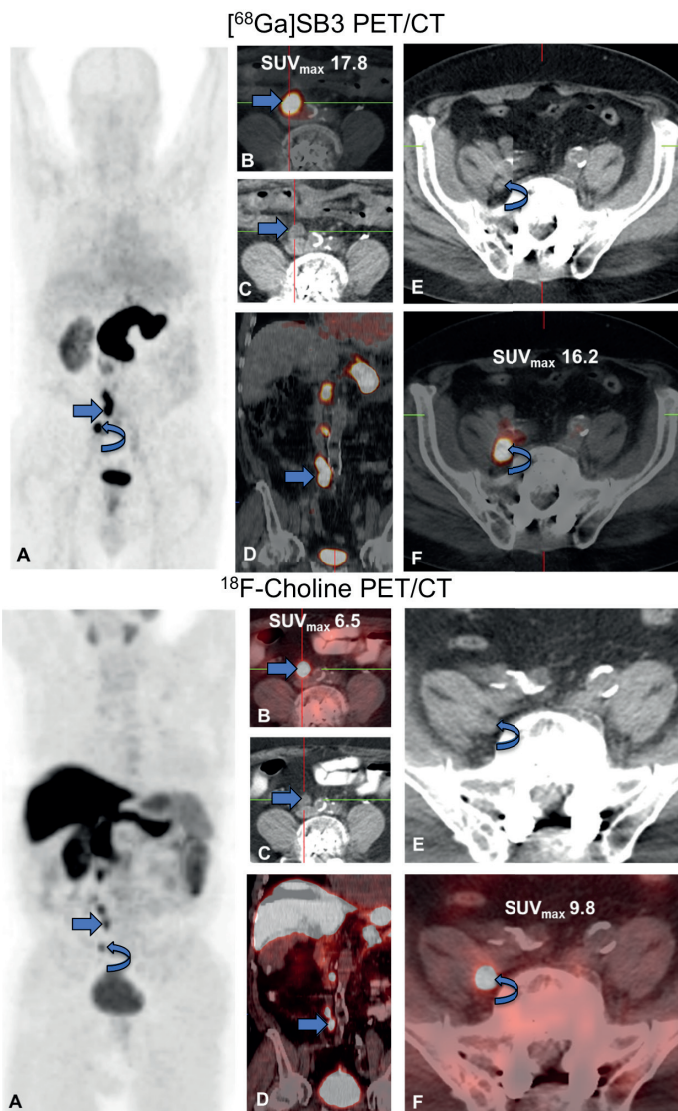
Top ^{68}Ga]SB3 PET/CT and bottom ^{18}F -choline PET/CT scan in a prostate cancer (PC) patient (number 4), demonstrating GRPR-positive and choline-avid lymph node metastases respectively: right to the aortic bifurcation (B–D, straight arrow) and right iliac lymph node metastasis at the level of the S1 vertebra (E, F, curved arrow). A MIP; B, F fused axial PET/CT images; C, E axial CT images; D fused coronal PET/CT image.
